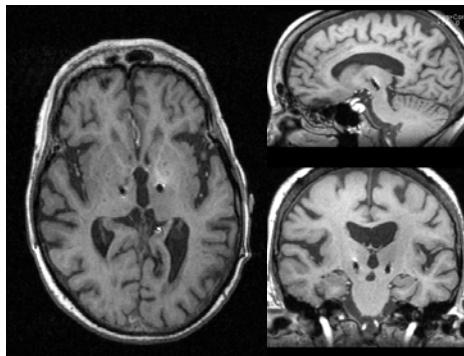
MRI of the Brain 11 years 5 months (06/07) after initial Implantation. Bilateral Vim Electrodes are visible.
